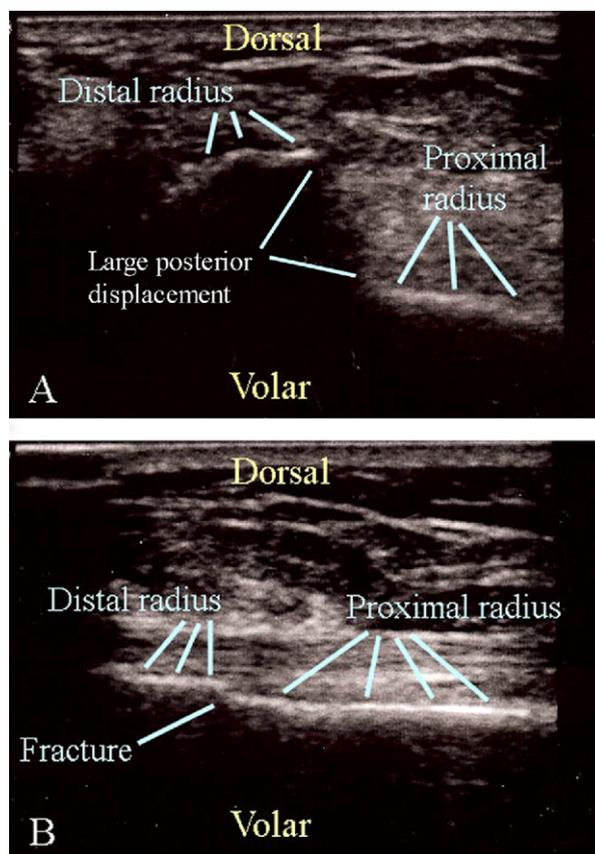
Pre- and post-reduction ultrasound images of a distal radius fracture. The pre-reduction image (A) demonstrates significant dorsal displacement of the distal radius. Post-reduction image (B) demonstrates good alignment with minimal displacement.
